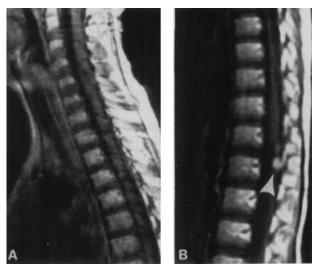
Post-contrast sagittal T1-weighted images performed in December 1993 on patient in Case 2, 7 months following completion of chemotherapy, show complete resolution of tumor deposit at the level of C2 (A) and partial resolution of the two nodules at the level of the conus medullaris (B, arrowhead).
